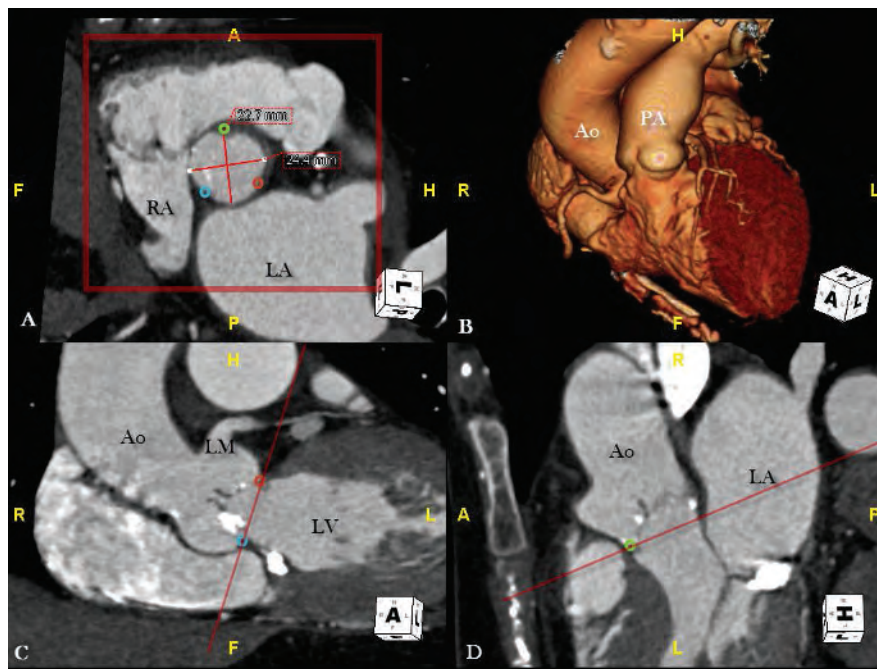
Multimodality computed tomography. Gated cardiac study demonstrating aortic valve basal annulus. (A) Short axis of basal annulus. The annulus is oval with minor axis of 22.7 mm and major axis of 24.4 mm. The circles demonstrate the most inferior portion of the respective cusps. Red, left coronary cusp. Blue, noncoronary cusp. Green, right coronary cusp. Red square, imaging plane demarcated by red line in panels C and D. (B) Three-dimensional cardiac rendering. (C) Long-axis view of aortic valve with most inferior portion of left and noncoronary cusps demonstrated. Red line is short-axis imaging plane. (D) Long-axis view of aortic valve with most inferior portion of right coronary cusp demonstrated. Ao, aorta; LA, left atrium; LM, left main (coronary artery); LV, left ventricle; PA, pulmonary artery; RA, right atrium;
